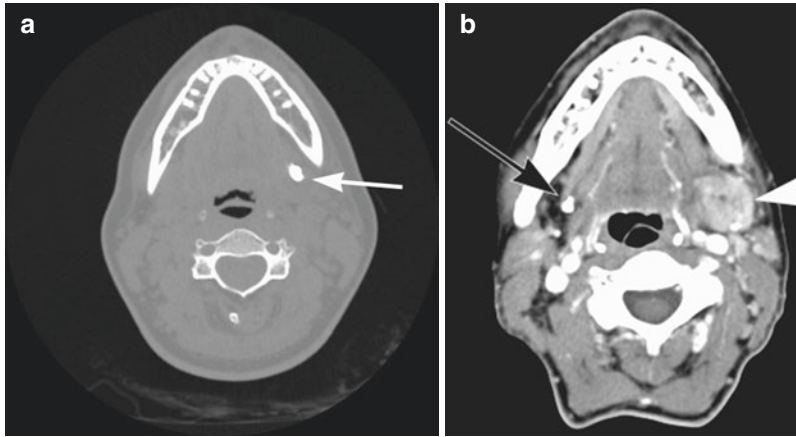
CT scan without contrast (a) with left submandibular calculus at the hilum of the gland (*white arrow*). A patient with chronic salivary obstruction (b) from a right submandibular duct stone (*black arrow*) has atrophy of the right submandibular gland and replacement of the space
